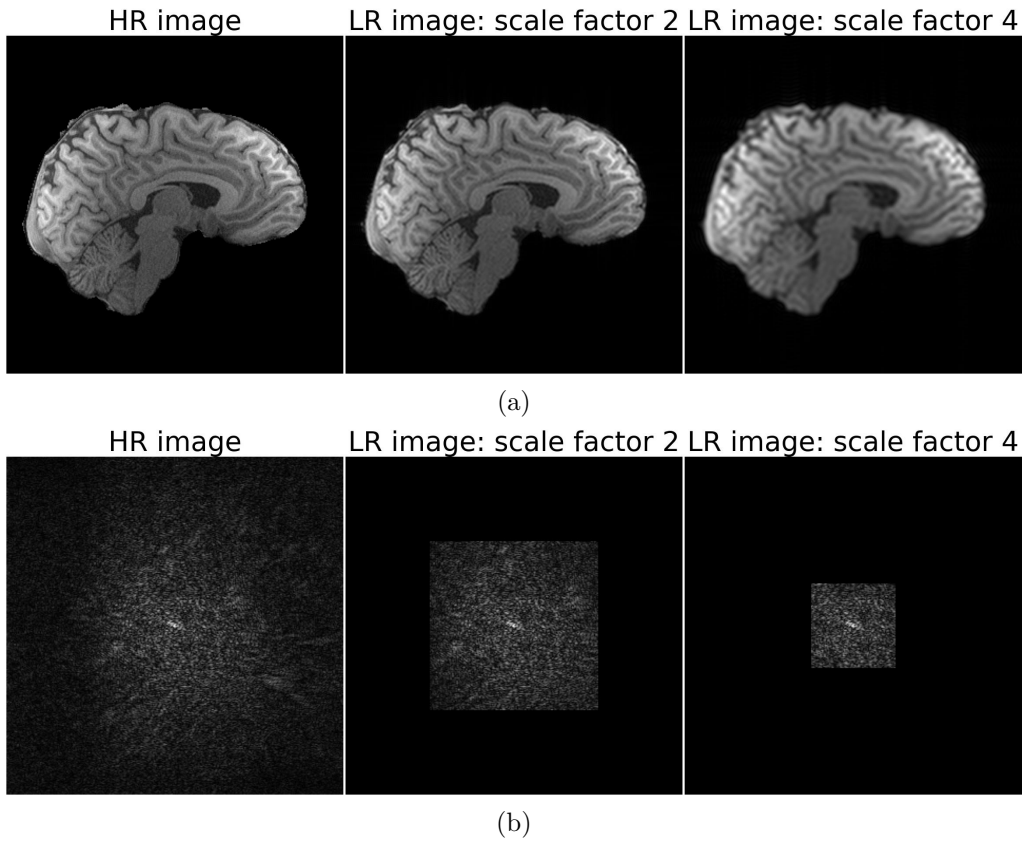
MR image and corresponding k-space data comparisons using different scale factors. In (a), from left to right, it shows the original HR image, and LR image using a scale factor of 2 and 4. (b) shows the corresponding k-space data using different scale factors. For scale factors 2 and 4, the central 25% and 6.25% of the data are preserved.
